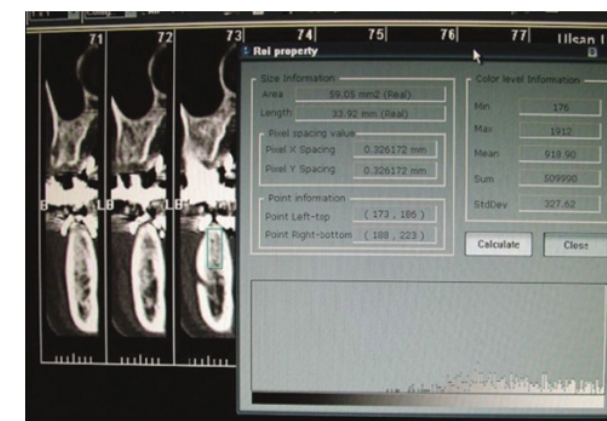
Image of transaxial cut of Somatom computed tomography (CT). The hounsfield unit (HU) measurement feature of CT was utilized to evaluate the bone density.
